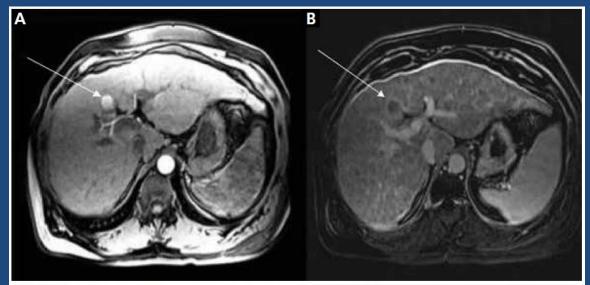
Left, arterial hyperenhancement of hepatocellular carcinoma seen on dynamic computed tomography. Right, venous-phase washout of contrast medium.
